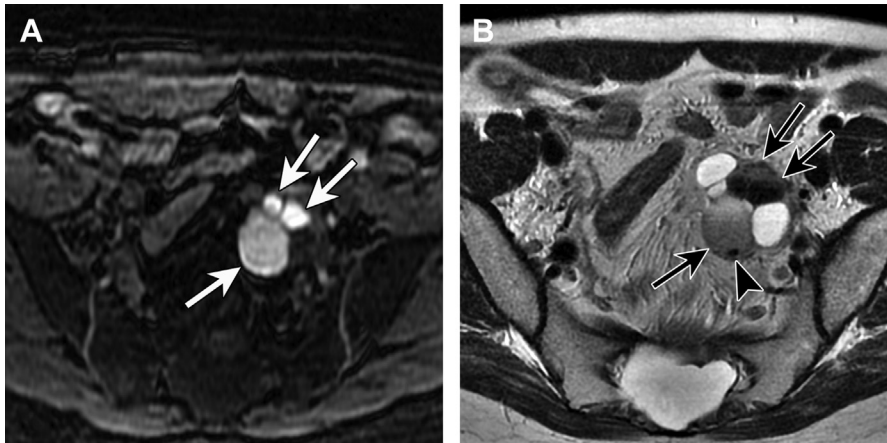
T2 dark spot sign in an endometrioma. Axial T1-weighted MR image (A) shows homogenous hyperintense signal in multiple left endometriomas (*white arrows*). Axial oblique T2-weighted MR image (B) shows the corresponding variable appearance of T2 shading (*black arrow*) and a T2 dark spot (*black arrowhead*) in a posterior endometrioma. Incidental follicles present.
